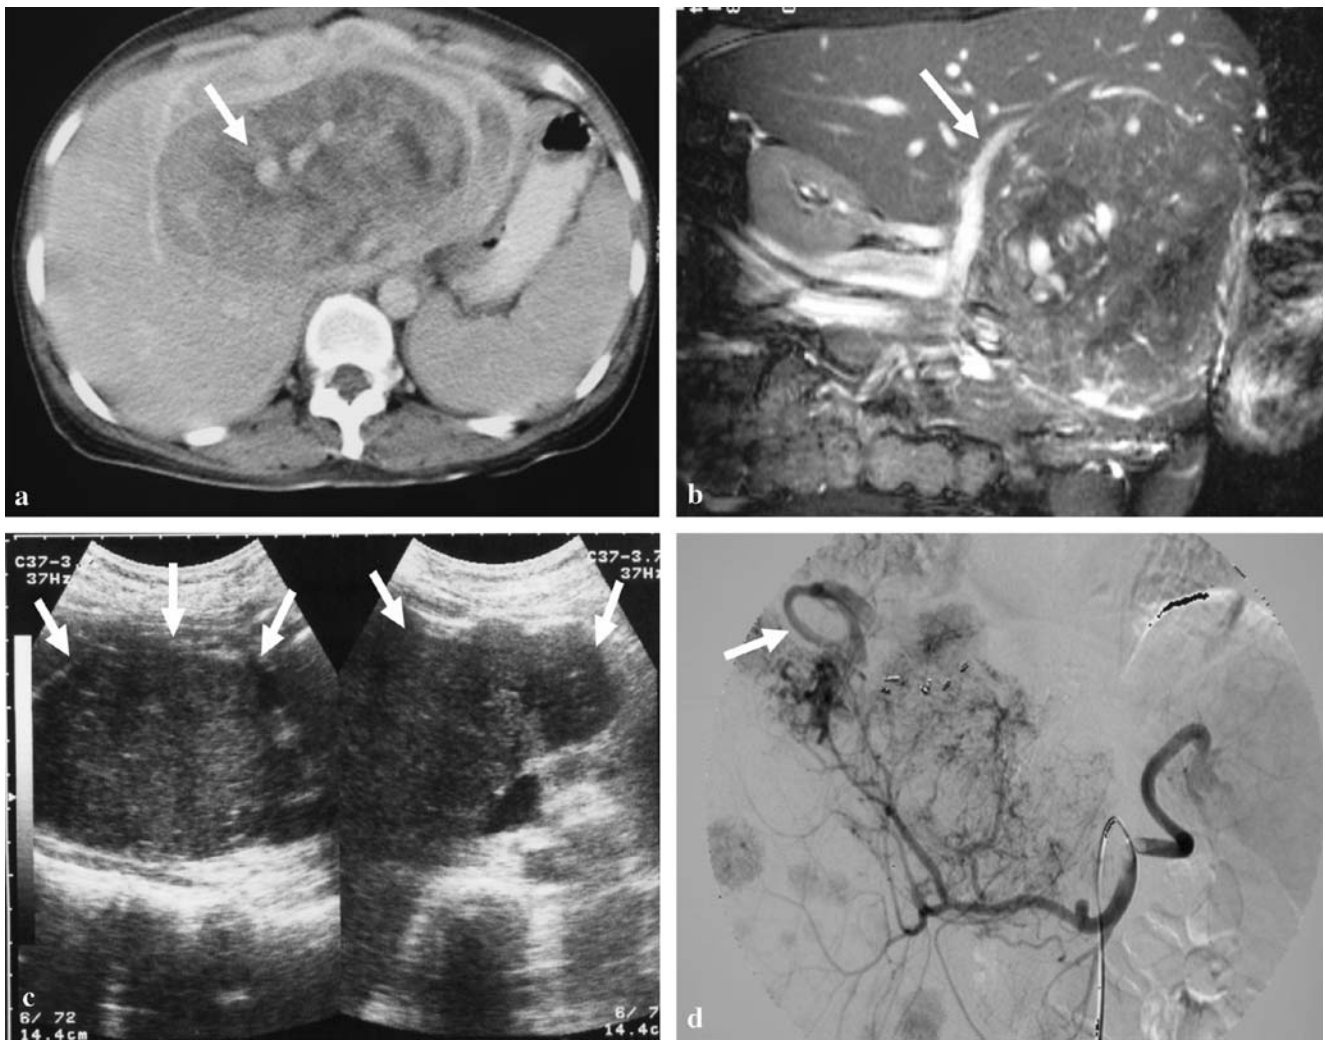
A 37-year-old woman (case 3) presented with fever and palpable abdominal mass. (a) The axial view of contrast-enhanced CT scans on portal venous phase shows a huge hepatic tumor at the left hepatic lobe with heterogeneous enhancement. Notice the engorged vessels within the tumor are vividly identified (arrow). (b) The MR coronal Tru FISP, fast imaging with steady-state precession. (TR/TE/FA=4.3/2.1/72°) shows engorged vessels in the tumor. The right portal
